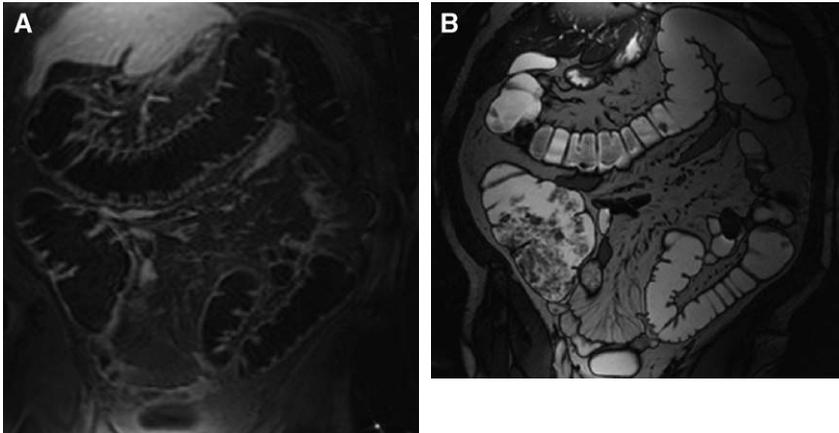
Using a combination of oral and rectal stool softener, signal intensity of fecal material can be adapted to the low signal of the rectal enema on the T1-weighted sequences (A). Thus, stool becomes virtual invisible and a diagnostic image quality can be achieved; however, diagnostic accuracy of TrueFISP images is limited because stool impresses as dark-filling defects on the bright colonic lumen (B).
